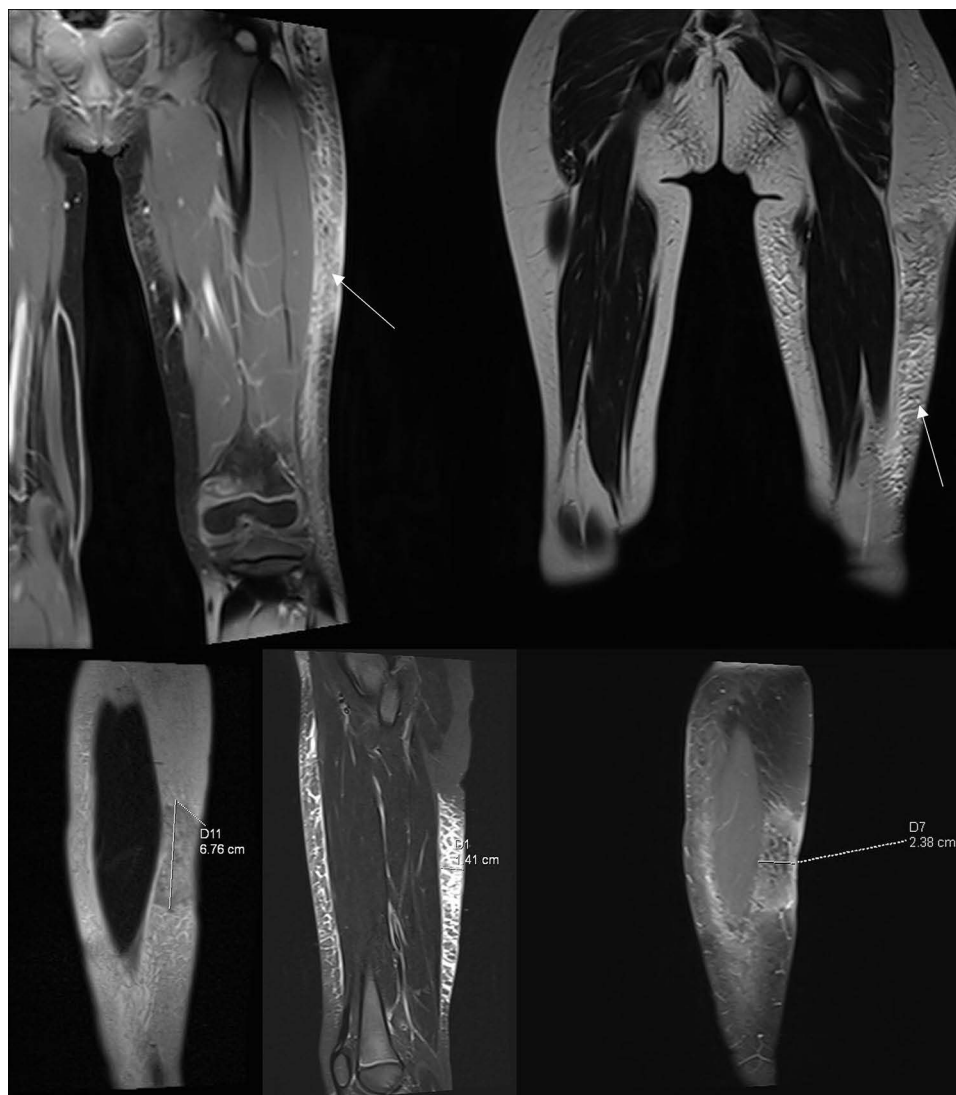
MRI image of the SPTCL lesion of the left thigh before treatment. Infiltrates with lymphoedema morphology, with a diffuse area of reduced signal intensity (60 x 20x70 mm), most likely corresponding to a neoplastic infiltrate. The lesion was measured and marked with a white indicator in the figure.
